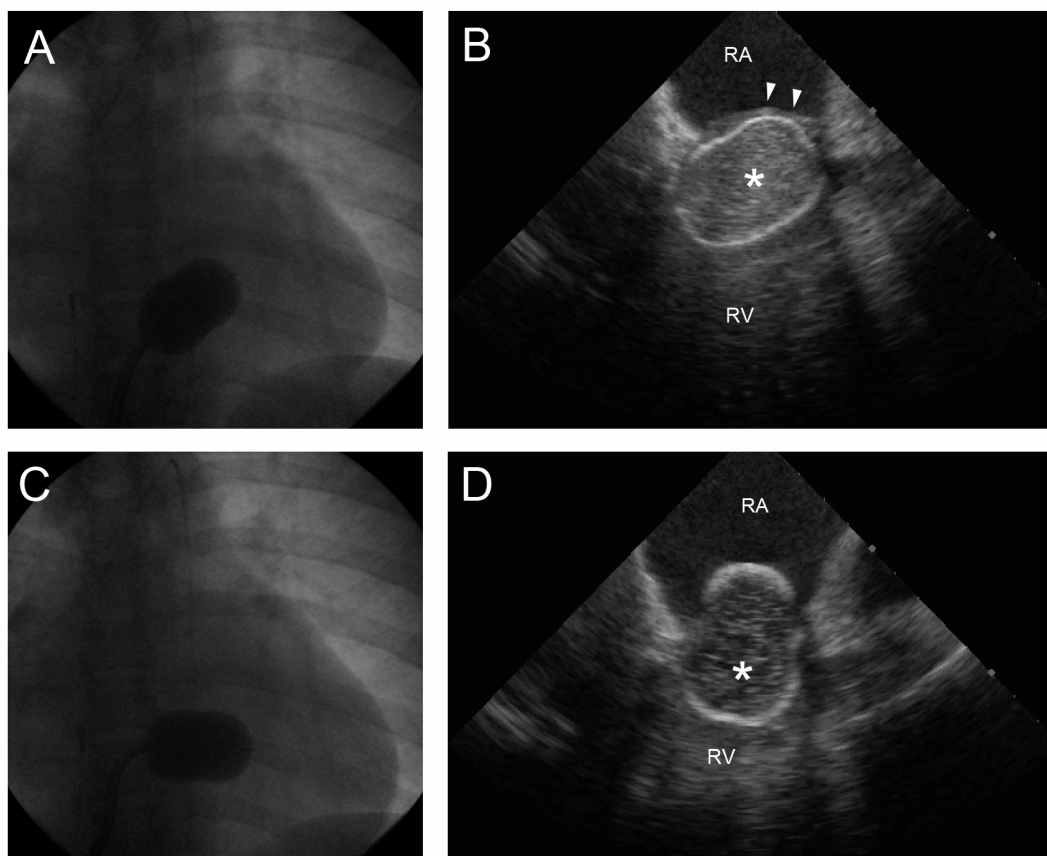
Inflation of the Inoue balloon in the right ventricle just below the tricuspid valve (upper) imaged with (A) fluoroscopy and (B) intracardiac echocardiography (ICE). Inflation of the Inoue balloon across the tricuspid valve imaged with (C) fluoroscopy and (D) ICE. The asterisk indicates the Inoue balloon, and the arrowhead the tricuspid valve. RA: Right atrium; RV: Right ventricle.
